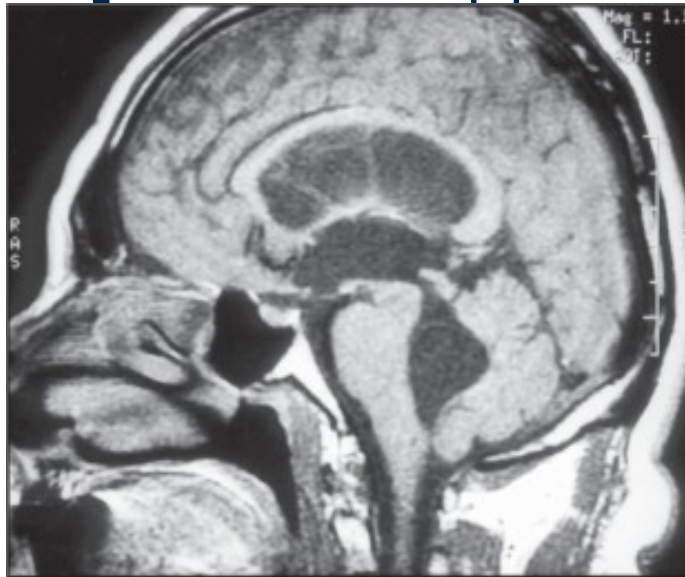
Preoperative sagittal T1-MRI with gadolinium demonstrating dilatation of the ventricular system and a non-enhancing cyst in the fourth ventricle.
